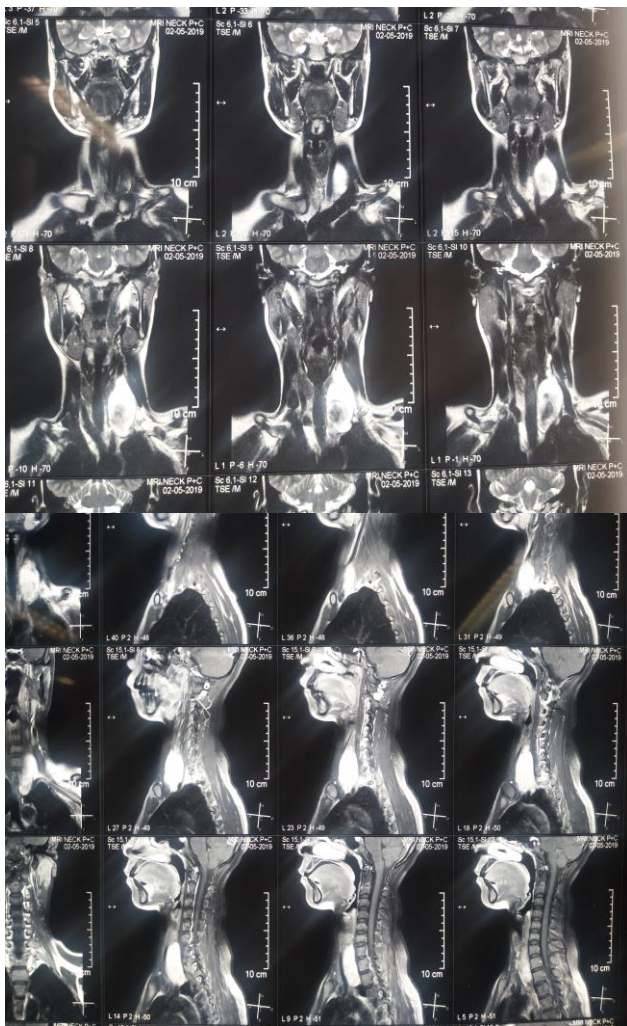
MRI neck with contrast: moderately enhancing lesion of size 7×4×3 cm in the left carotid sheath.
